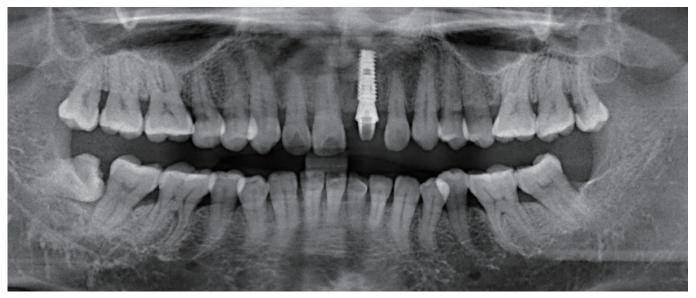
Post-op panoramic x-ray.
